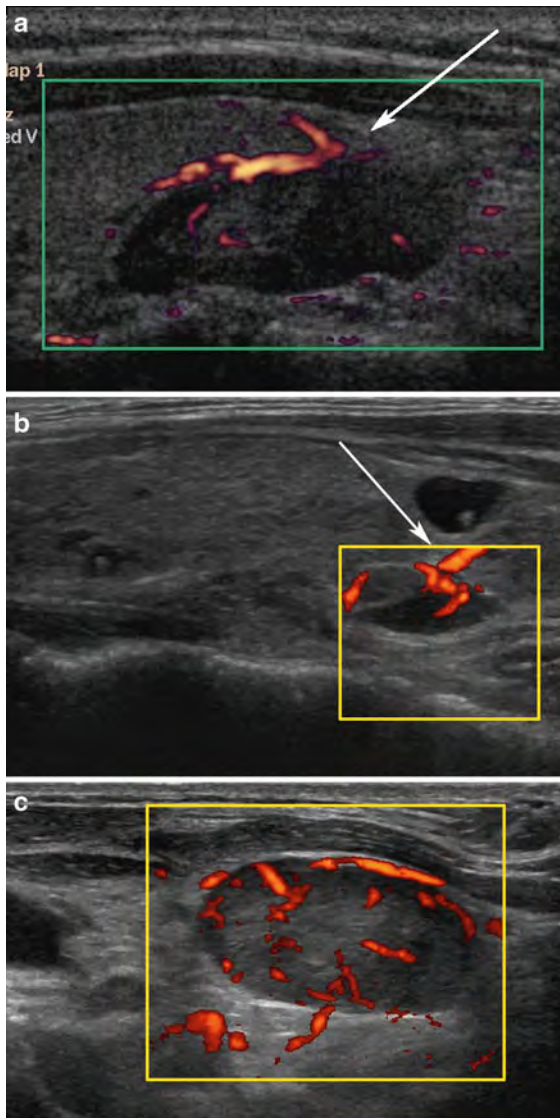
Power Doppler studies of three different enlarged benign parathyroid glands. a, b vascular supply from a single pedicle which is not polar and appears to arise from the thyroid gland (*arrows*) and c a more chaotic pattern of vascularity
